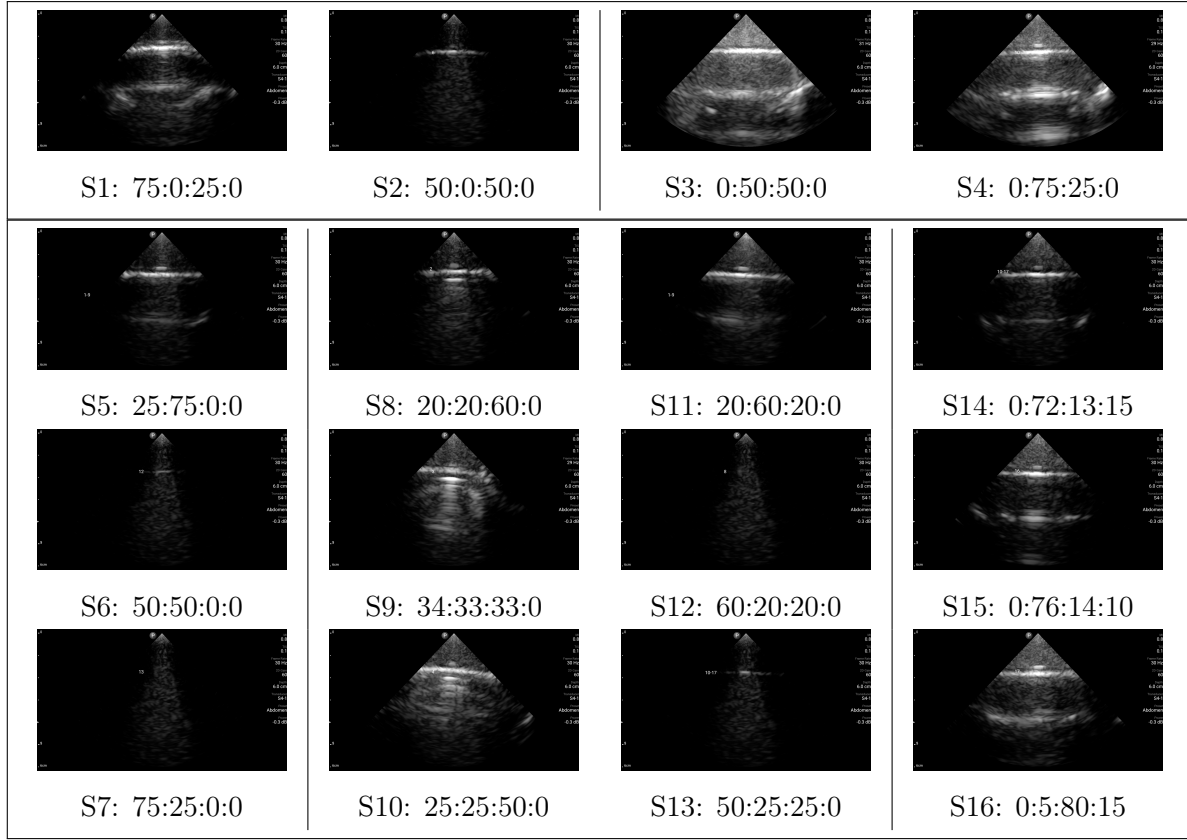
Raw ultrasound images of printed test coupons (S1–S16) with varied J5 DAP material ratios of ElasticoClear:TissueMatrix:GelMatrix:DraftWhite (in %). Samples S1–S4 occupy the top row, while subsequent samples are arranged column-wise. The samples are arranged in sections based on the materials that vary within the samples. These images were used for assessing acoustic compliance and echogenicity.
